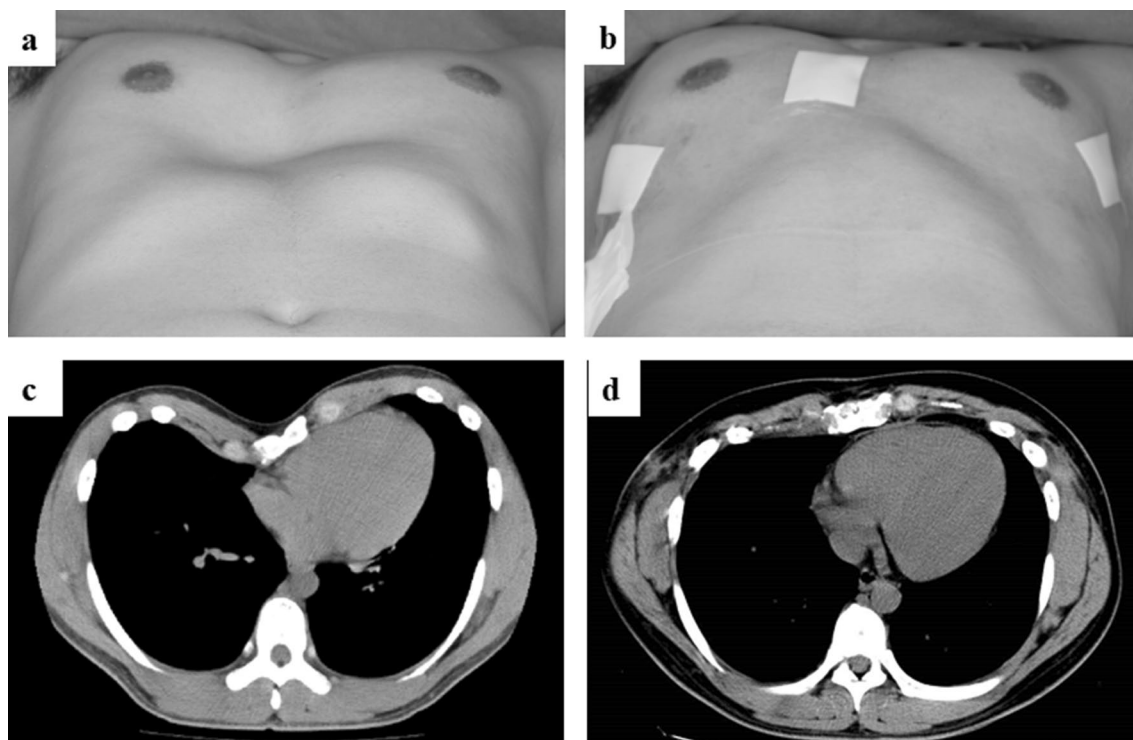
CT images and chest appearance before and after the Nuss procedure (patient two). a Preoperative chest appearance, b Postoperative chest appearance, c Preoperative CT images, d Postoperative CT images
